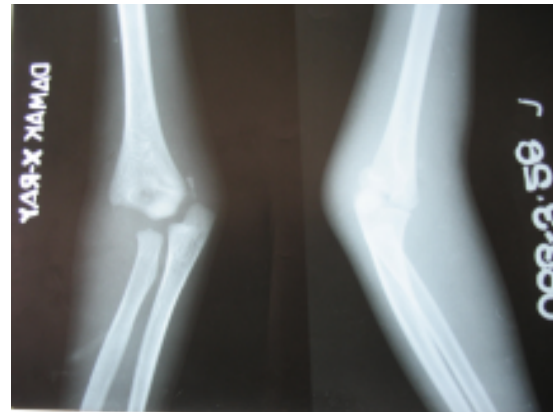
X-ray does not show distal humeral epiphyseal injury
